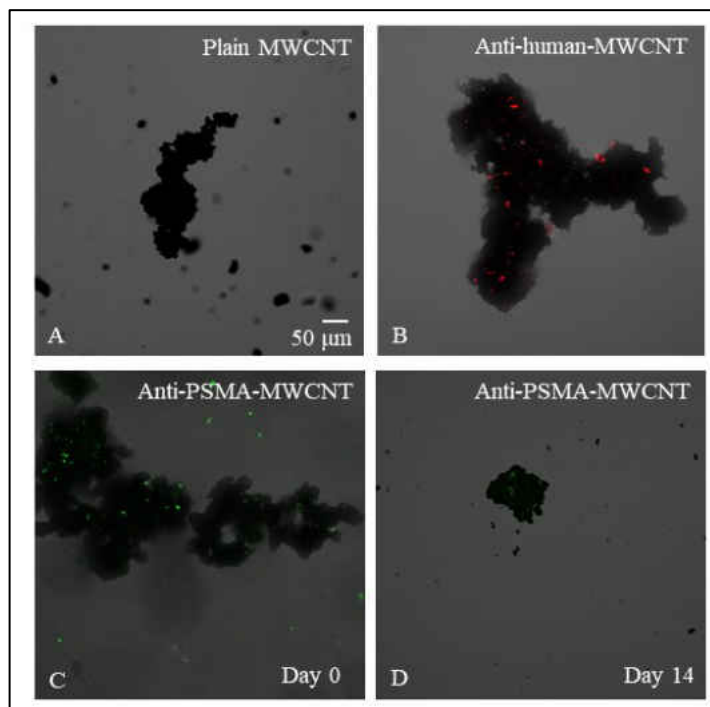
Analysis of antibody conjugation. Images compare plain MWCNT without antibodies (A) as compared with MWCNTs conjugated with anti-human AlexaFluor647® (B) and anti-PSMA AlexaFluor488® on the first day of synthesis (C) and on day 14 (D). 400X Total Magnification.
